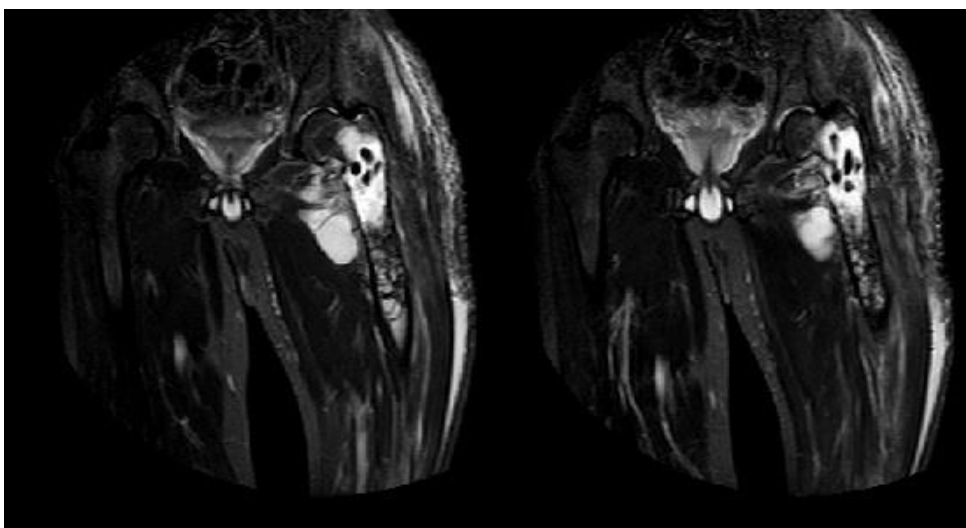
5. Continuous MRI sections of the patients left femur demonstrating the widespread lesions of cyst hydatid.
